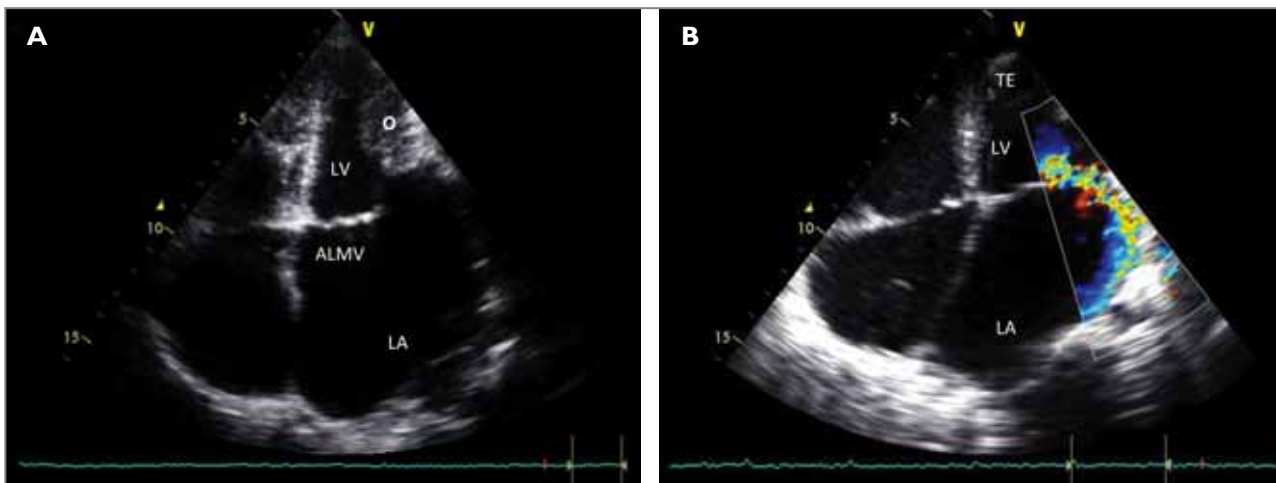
2D echocardiogram in apical 4-chamber view in a patient with predominant left Endomyocardial Fibrosis. The left ventricle (LV) is small. The anterior leaflet of the mitral valve (ALMV) is diffusely thick; the posterior leaflet cannot be seen due to its engulfment in the obliteration of the posterior mitral recess (O). This fusion of the posterior leaflet to the wall is the basis for non-coaptation and severe mitral regurgitation. The left atrium (LA) is aneurysmal while the left ventricle does not present dilatation.
